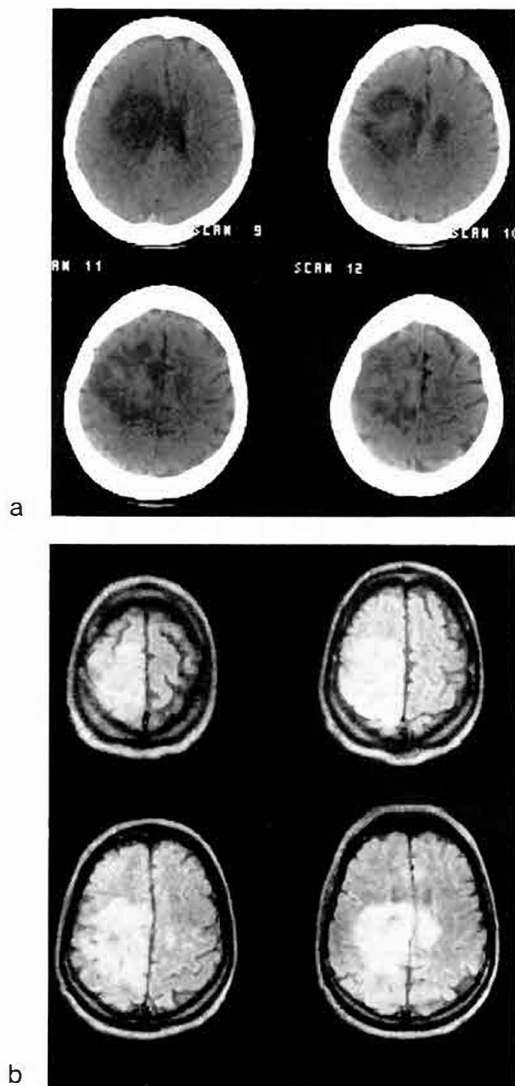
Unenhanced CT scans in a patient with allergy to contrast medium shows a lesion occupying a large space of the left parietal region with extending through the corpus callosum into the right hemisphere. The appearances are of a low grade astrocytoma.
